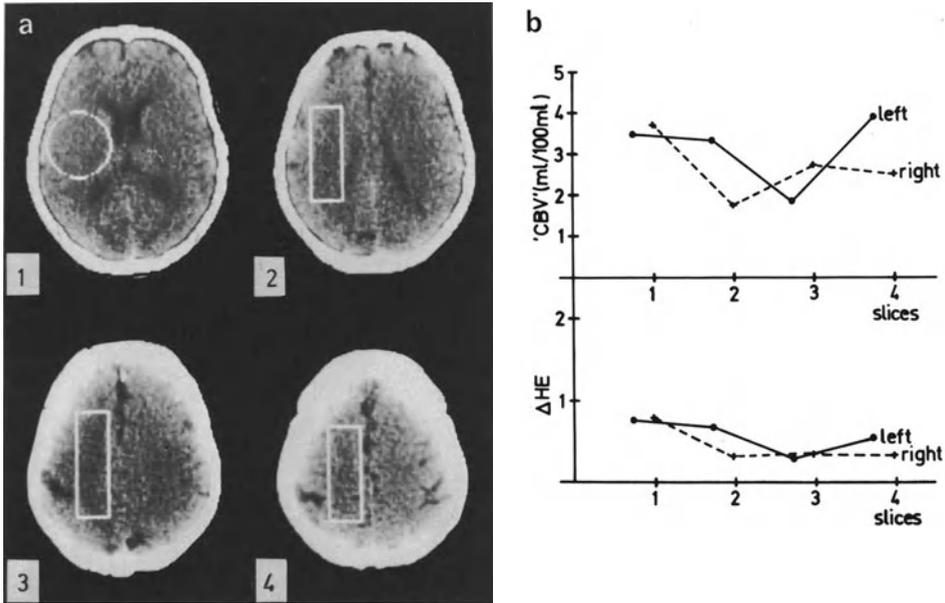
a, b. Normal "CBV": Essentially normal CT scan in a 56-year-old female with acute Guillain-Barré syndrome (a). The pertinent Δ HE and "CBV"-values in the indicated ROI ranging between 2 and 4 ml/100 ml (b) are regarded as "normal" according to similar results in 5 other "normal" scans. (For improved clearness, ROI is outlined only on the left)
